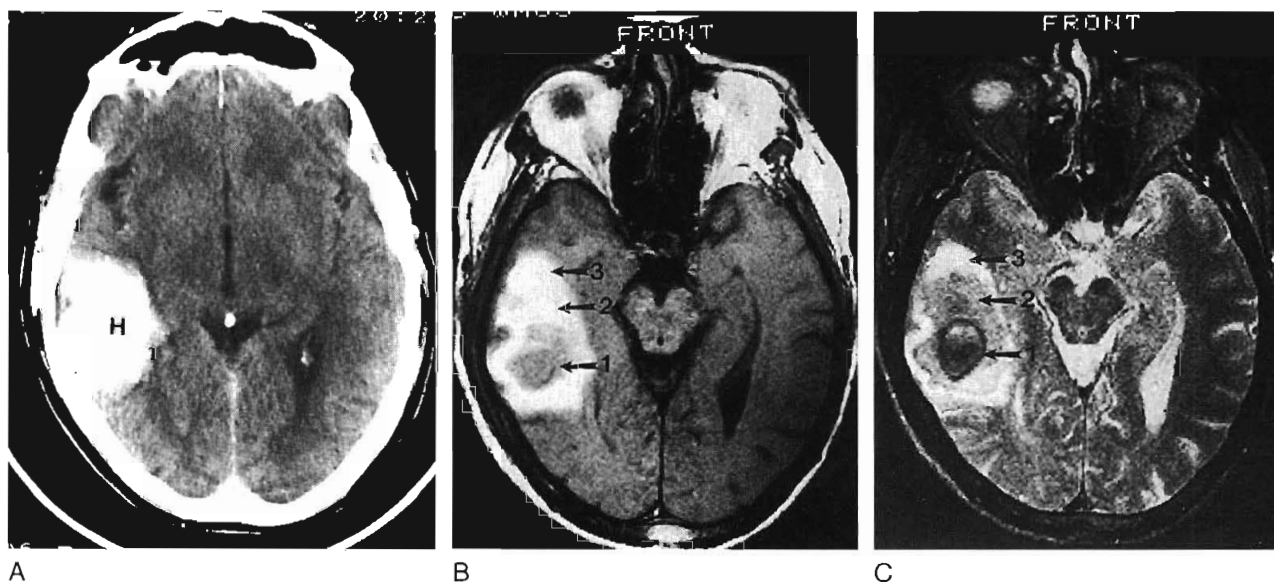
Hemorrhage. Axial CT image (A) demonstrates a large area of acute hemorrhage (H) in the right temporal lobe. T1-weighted (B) and T2-weighted (C) MRI scans demonstrate the hemorrhage in various stages of breakdown. The center of the lesion is dark on the T1- and T2-weighted images, indicating oxyhemoglobin (1). The intermediate zone is bright on the T1-weighted image and gray on the T2-weighted image, indicating intracellular methemoglobin (2). The outer rim is bright on both the T1- and T2-weighted images, indicating extracellular methemoglobin (3).
